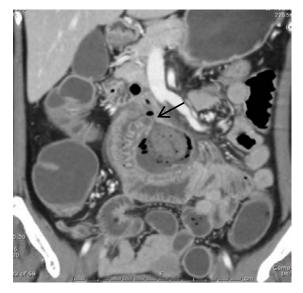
Contrast enhanced CT shows a defect (arrow) in the wall of jejunum, leading to abscess between jejunal loops. Operative findings reveal perforated jejunal diverticulitis.
